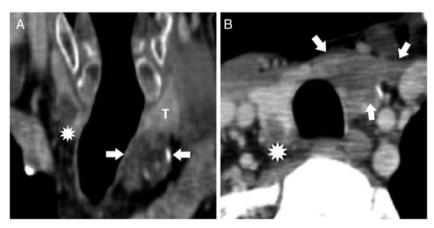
Multisection computed tomography in coronal oblique slices (A) and axial oblique slices (B) showed inhomogeneous, hypodense, partly calcified lesion (arrows) distinctly part of the left thyroid lobe (T) postoperatively confirmed as PC and well-bordered hypodense lesion in posterior part of right thyroid lobe (above asterisk) postoperatively confirmed as metastasis of primary tumor.
